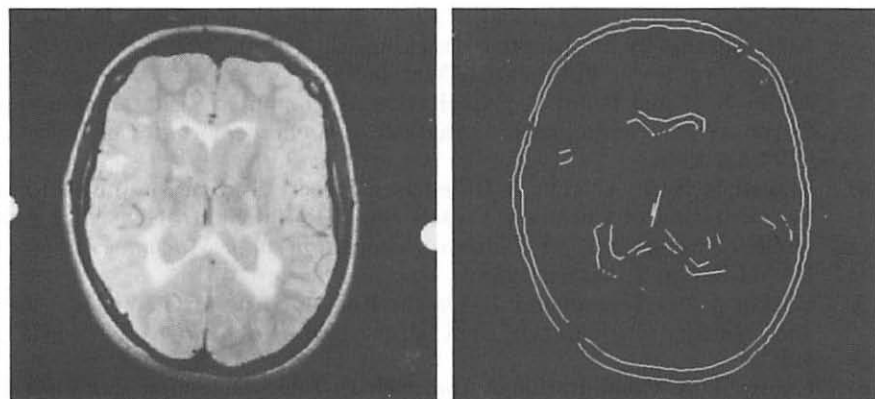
HEAD: The original image is an MRI image. The identified ribbons are shown on the right.
